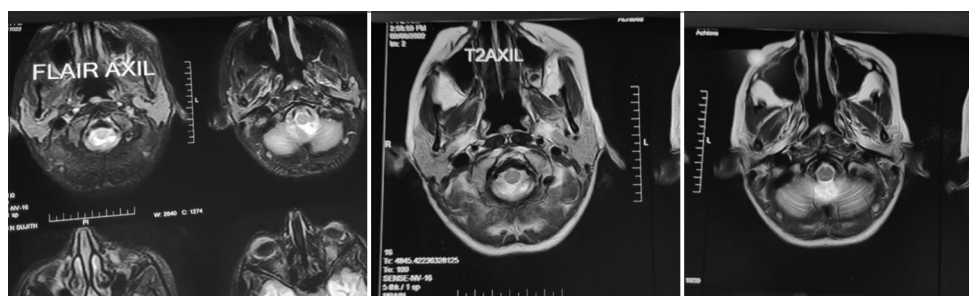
Magnetic resonance imaging of the brain revealed hyperintense signals on T2 and fluid-attenuated inversion recovery images in the pons and bilateral brachium pontis, suggestive of demyelination
